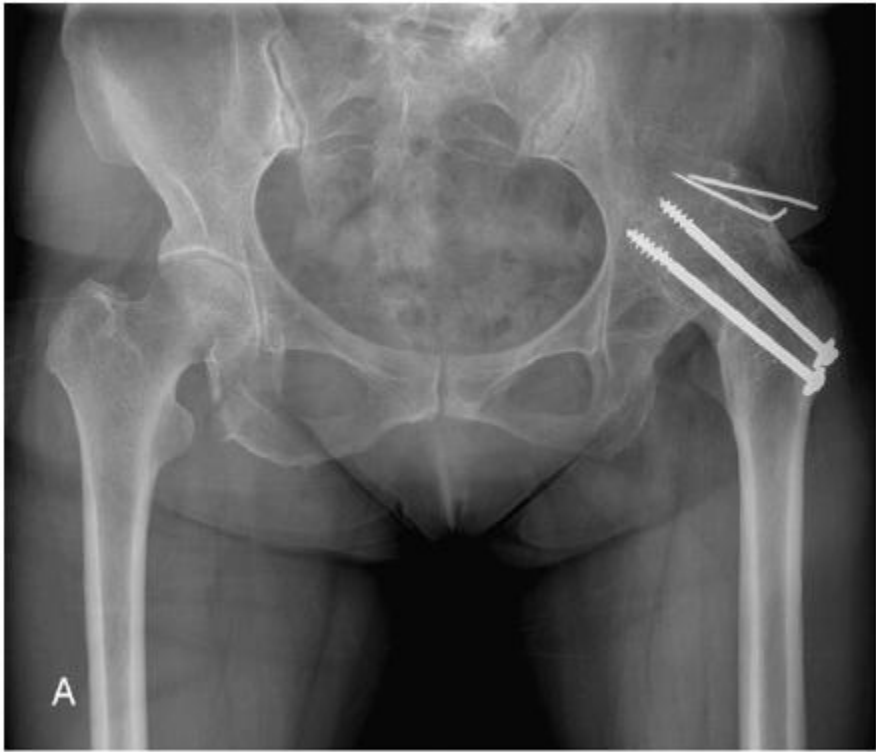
(A) Preoperative anteroposterior radiograph of a 68-year-old woman with left arthrodesed hip and (B) postoperative radiograph at 1-year follow-up.
